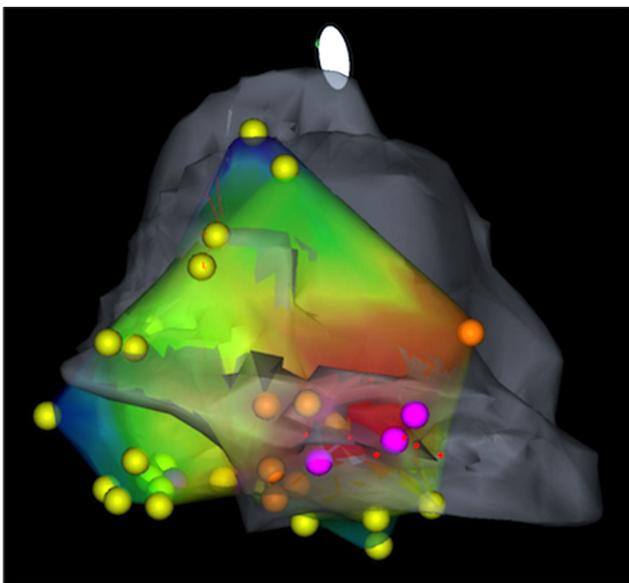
Pacemap and geometry constructed by ICE. Pink tags show the sites of perfect pacemapping. Light gray geometry shows the morphologic RV. (ICE: intracardiac echocardiogram, RV: right ventricle).
